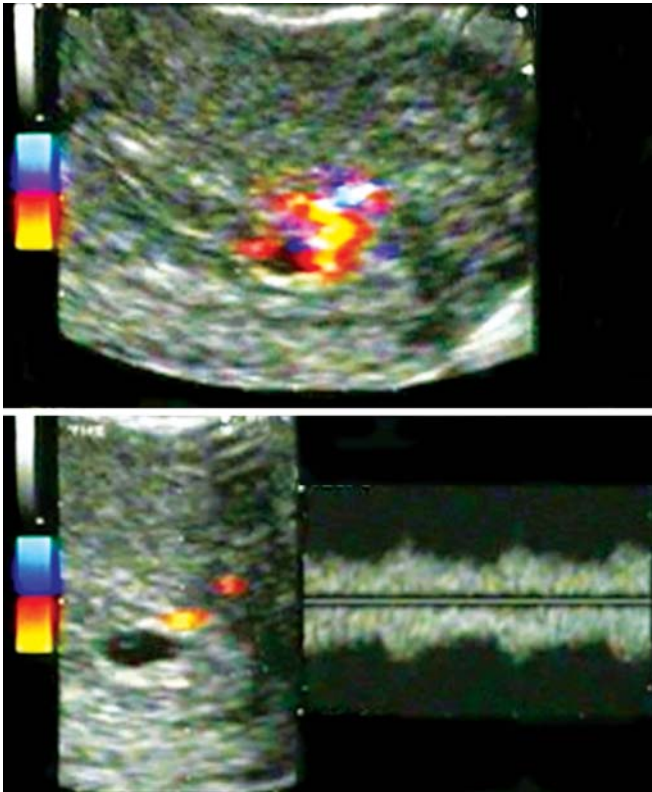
Image recorded by 2D color Doppler sonography, showing intervillosal blood flow
